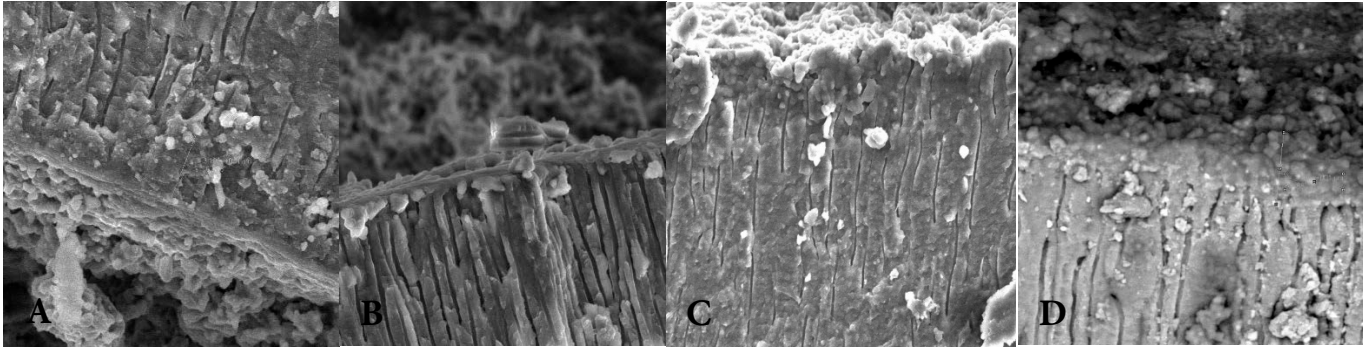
SEM analysis at 1000× magnification can be seen for the determination of the penetration of bioceramic sealer into the dentinal tubules in the apical third after agitation with A) Passive ultrasonic irrigation; B) 30-G needle in a syringe; C) XP-Finisher file; D) Er:YAG laser
